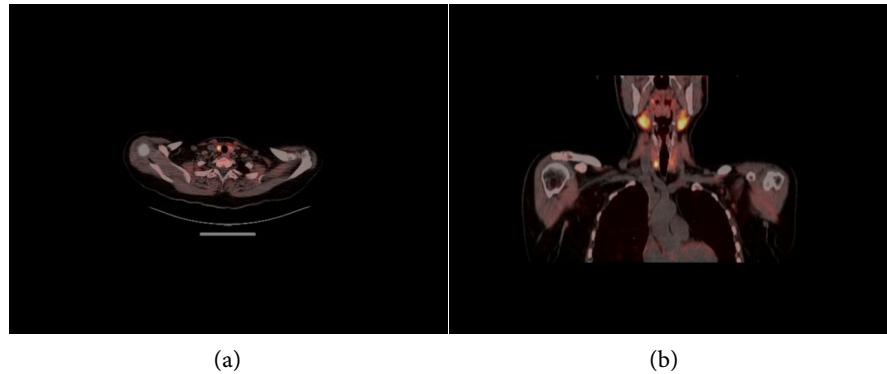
(a) ^{18}F -fluorocholine PET/CT early-phase imaging demonstrating focal tracer uptake within a right inferior intrathyroidal nodule, corresponding to the site of the parathyroid adenoma; (b) Delayed-phase ^{18}F -fluorocholine PET/CT demonstrating increased tracer uptake within the right inferior intrathyroidal nodule, confirming the presence of a parathyroid adenoma.
